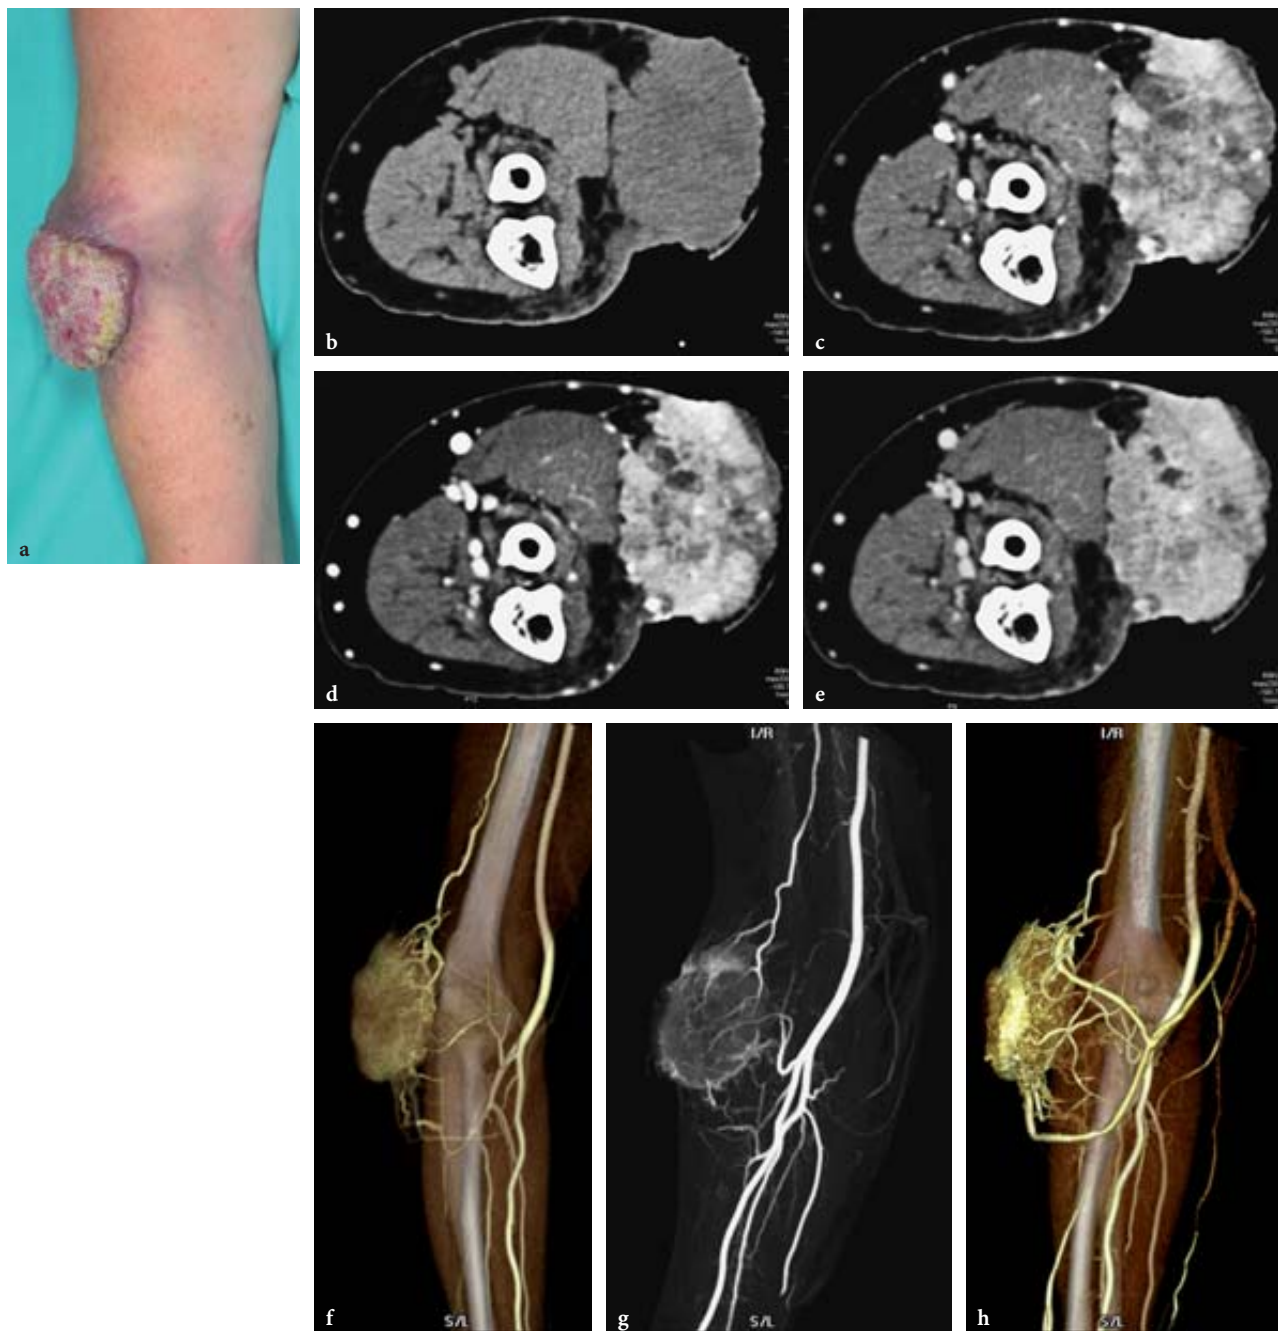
Multiphasic exploration with CT in a case of Merkel cell tumour of the elbow. Four acquisitions were performed with 80 kV and 230 mAs: before IV injection of contrast media and at the arterial, venous and equilibrium phases. a Photography of the elbow showing a large hypervascularized tumour. b–e Axial slices obtained at the different phases showing a large mass with a rapid initial enhancement followed by sustained late enhancement and some areas of necrosis highly suggestive of a malignant tumour. f, g Volume rendering technique (VRT) and maximum intensity projection (MIP) obtained from the arterial acquisition highlighting the three arteries feeding the tumour. h VRT obtained from the venous phase demonstrating the vascular relationship of the tumour as well as rapid venous opacification. In such cases, multiphasic MDCT provides a precise topographic and compartmental analysis of the tumour, a vascular map of the anatomical region and a dynamic evaluation of the lesion
